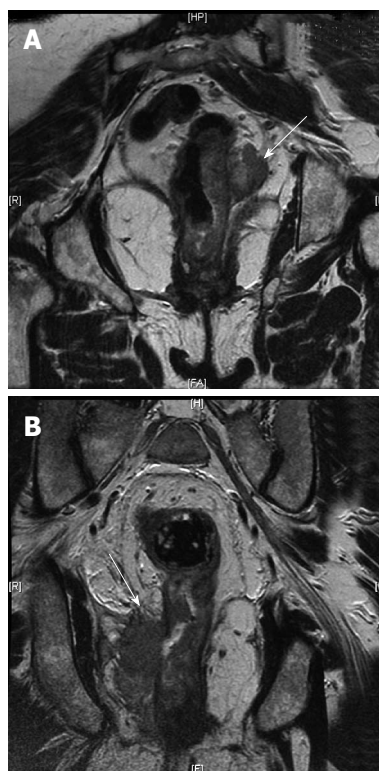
Magnetic resonance imaging. A: Magnetic resonance imaging (MRI) (arrow) showing the rectal cancer involving the circumferential resection margin; B: MRI (arrow) showing the rectal cancer invading the ischioanal fat on the right (T₄).
